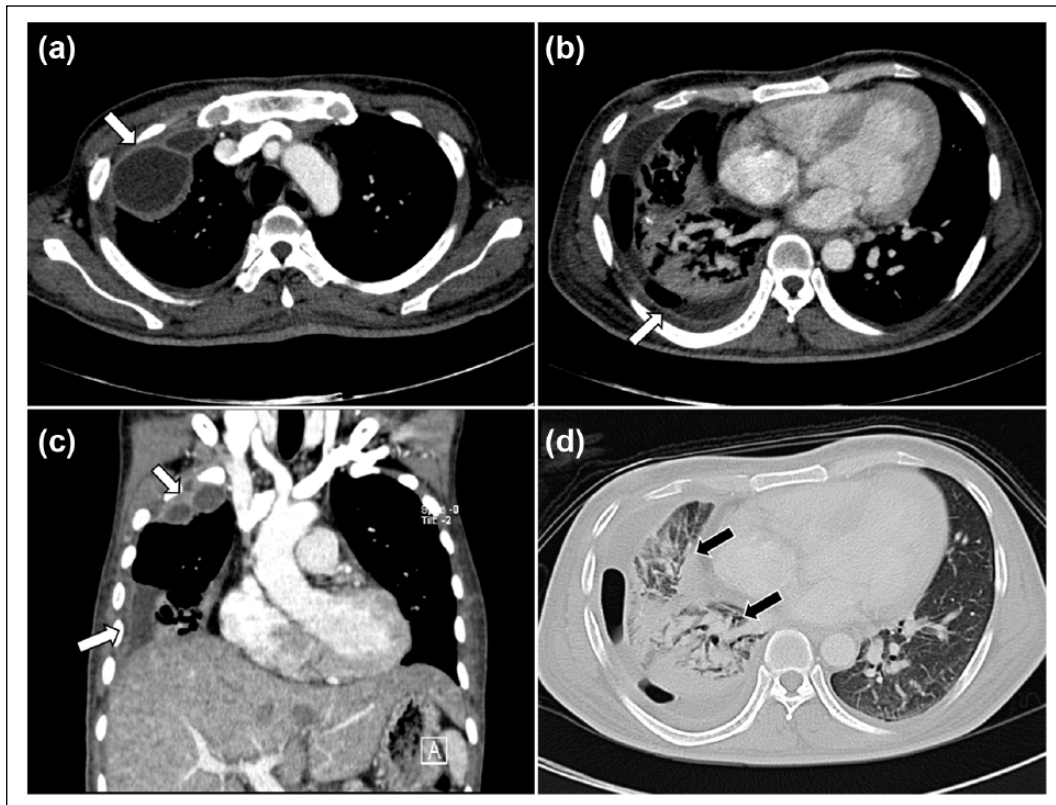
Selected axial ((a), (b) and (d)) and coronal (c) computed tomography images showing multi-loculated pleural collections with enhancing thickened pleura consistent with empyema in the right hemithorax (white arrows). In addition, there are consolidations in the right lower and middle lobe (black arrows).
